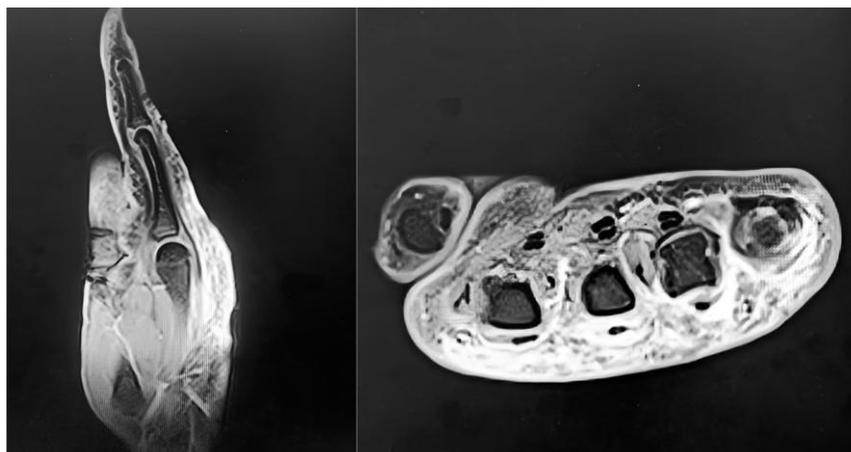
Preoperative MRI of the left hand showing peritendinous edema and a hypointense fibrotic band encasing the extensor tendons (compartments II–V).
